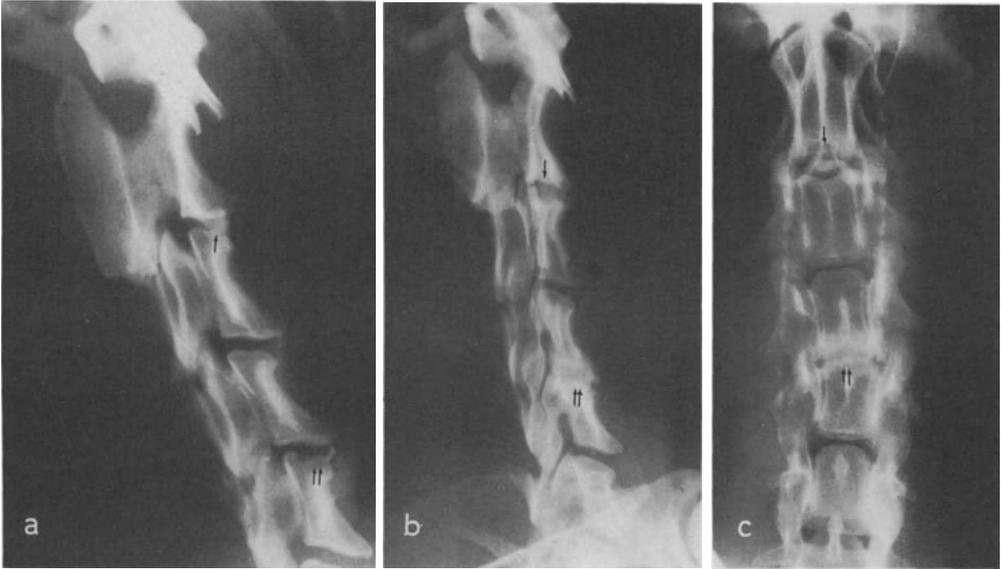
Lateral and sagittal X-ray projections of the cervical spine C 2/3 - PMMA †, C 4/5 - autogenous bone ‡. a Phase I - immediately after operation; b, c Phase III (217 days after surgery) halo at C 2/3; complete osseous fusion at C 4/5
